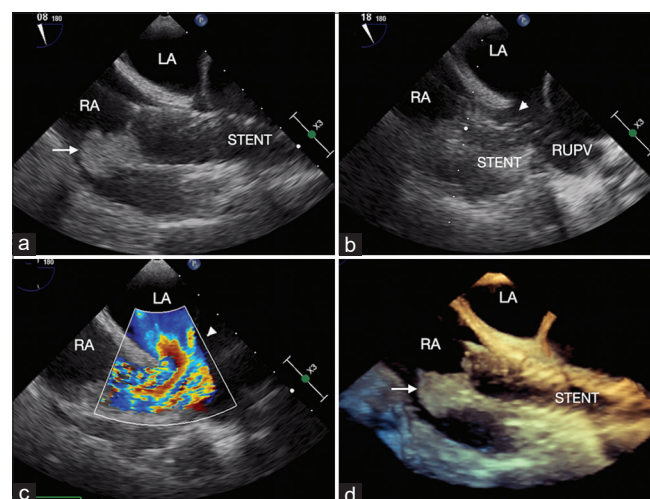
Bicaval view on transesophageal echocardiography (a) showing a thrombus at the right lower end of the covered stent in the RA. A rightward sweep (b) demonstrates a small residual defect (small arrow) with color flows (c). Three-dimensional echocardiogram (d) shows the thrombus in the RA and the smooth surface of the LA. RA: Right atrium, LA: Left atrium. White arrow indicate the thrombus
